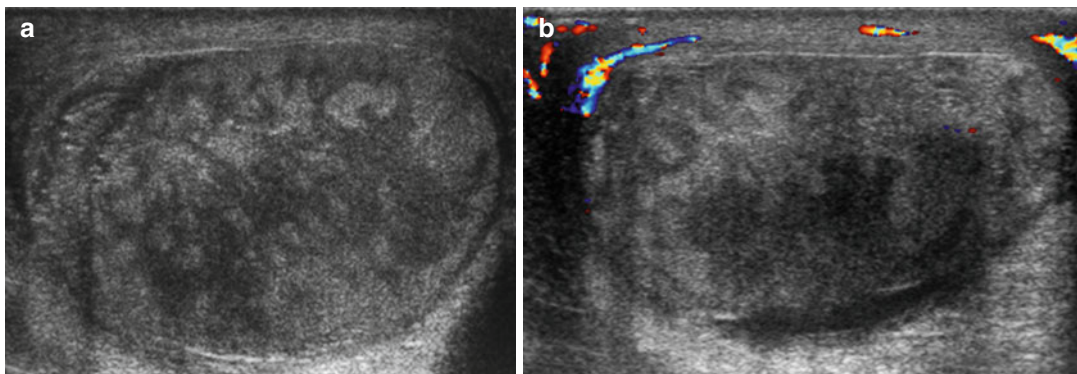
Ultrasound longitudinal scan shows a case of extravaginal torsion in a newborn with a palpable mass above the scrotum without evident acute pain; (a,b) the testicle is swollen and heterogeneous
